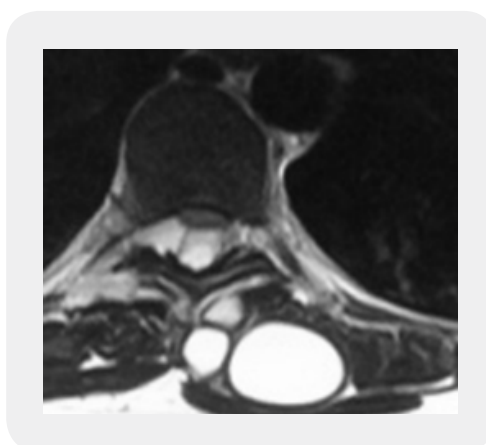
T2-weighted axial spinal MRI: extradural, multi-vesicular cystic lesion, and with spontaneous hypersignal
